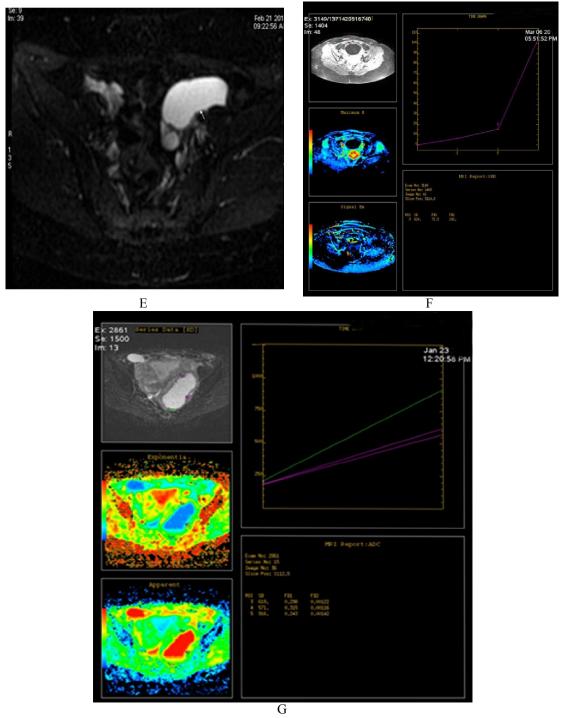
(A-G): Complex haemorrhagic bilateral adenxal cysts in a 40 year-old woman (a) Unenhanced T1-weighted axial image. (b) T2-weighted axial image. (c) FAT-SAT T1-weight axial image show well circumscribed adenxal cysts at right and left ovaries, the left one shows predominantly hyperintense signal anteriorly, a findings suggesting blood which confirmed by non drop of signal at FAT-SAT image, and an area of low signal posteriorly as well as at right ovary and may represent debris, blood and serous fluid, (d) Diffusion-weighted (b=1000 sec/mm2) show low signal intensity. (e) Corresponding ADC map shows high signal intensity, suggesting a benign cysts. (f,g) graphs show dynamic enhanced curves.
